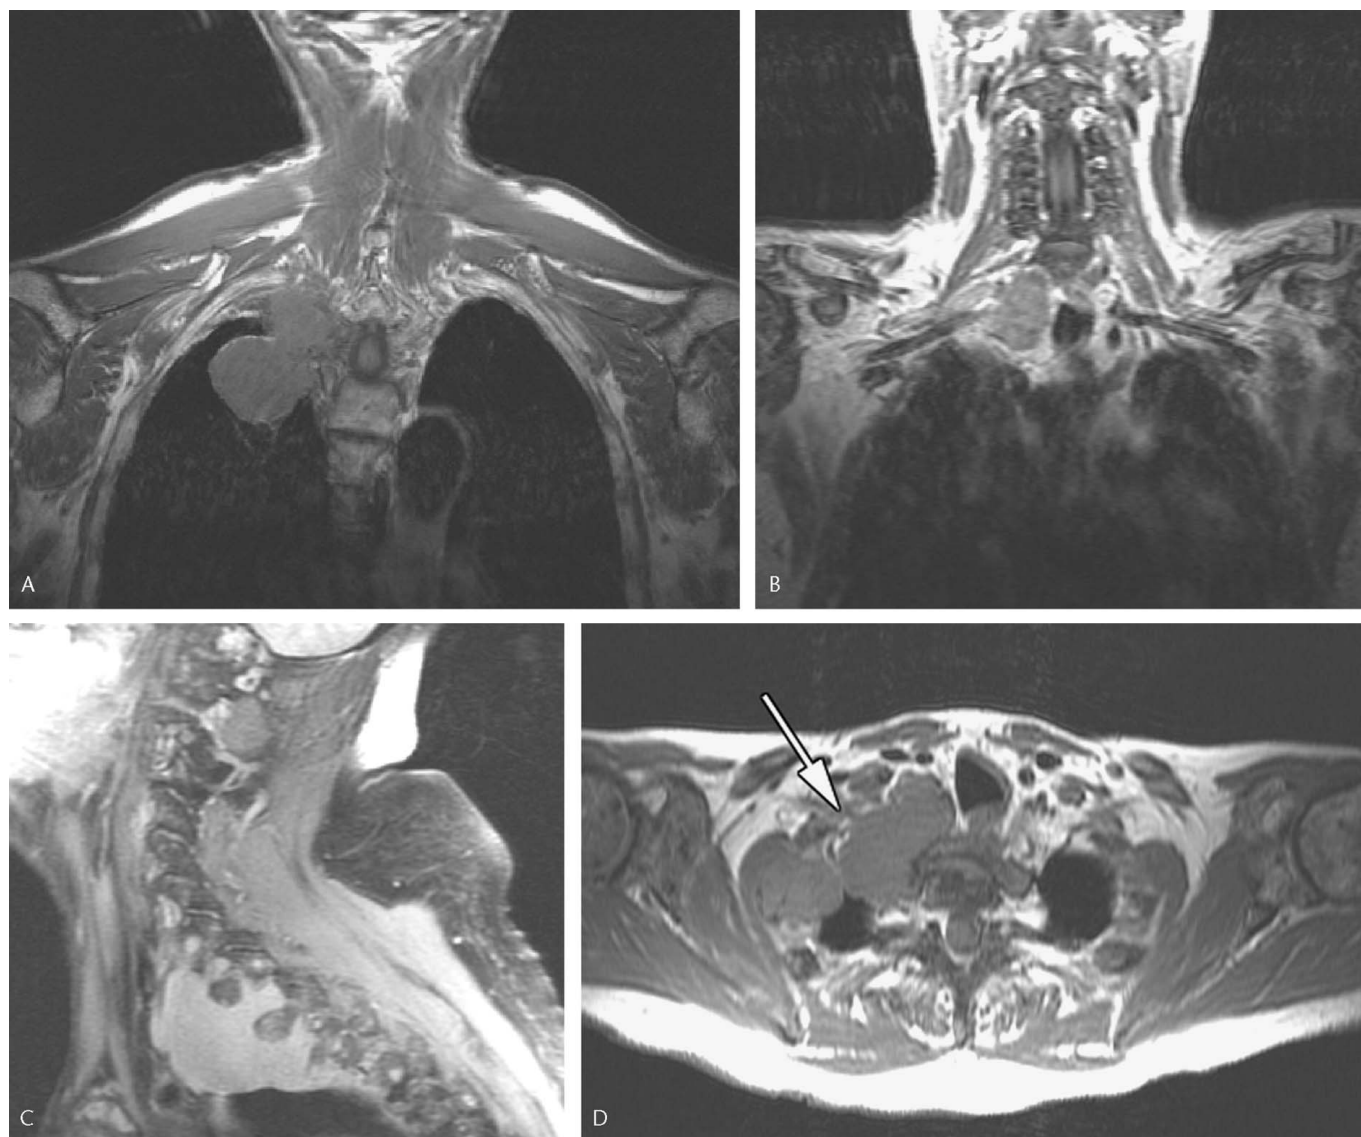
Direct extension of primary lung cancer in two patients. A, Coronal T1-weighted image demonstrates right apical lung mass with extension to the brachial plexus. B, Coronal T1-weighted image in second patient demonstrates a right apical lung mass (arrow) with extension to the brachial plexus (arrowhead) in a second patient. C, Sagittal T2-weighted image shows same mass as in second patient. D, Axial T1-weighted image shows same apical lung mass as in second patient.
